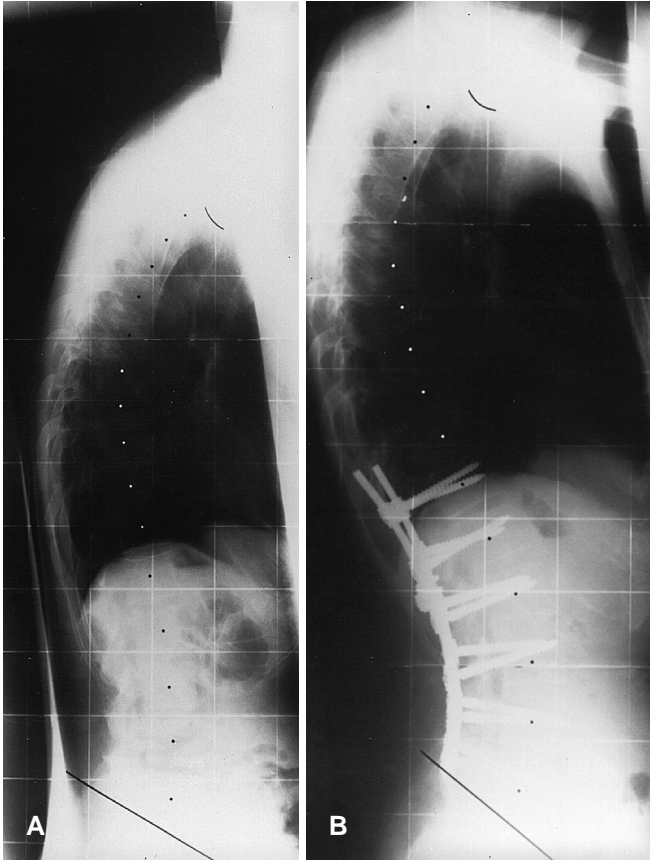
D Pre- and postoperative lateral radiographs with a follow-up of 82 months after polysegmental lumbar osteotomies and correction with the USIS transpedicular instrumentation (case 12). There has been  $36^\circ$  of correction. Loss of correction is  $33^\circ$  at follow-up. Note the rod breakage in the highest two levels and failure at the junction of the pedicle screw and the rod in the lowest level of the USIS instrumentation
